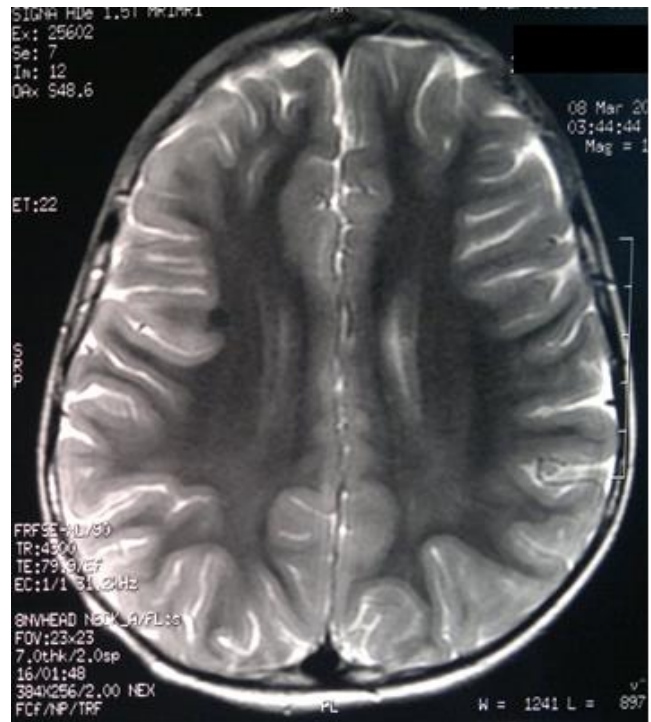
Repeat MRI showing normal picture with resolution of the abnormal signal intensity.
